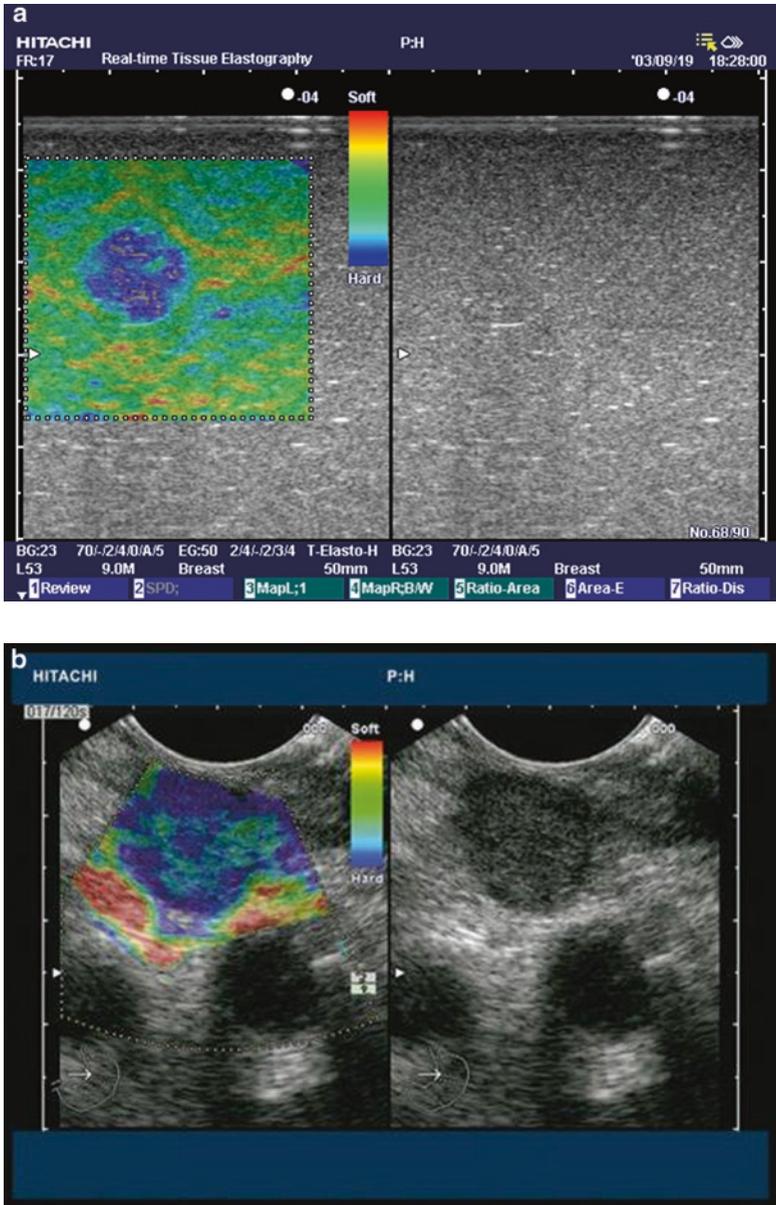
(a, b) Elastography interrogates the relative compressibility of adjacent tissue in response to manual pressure applied with the transducer. Relatively compressible tissue is displayed as green on the ultrasound image, whereas less compressible (and presumably more likely to be malignant) tissue is displayed as purple.
